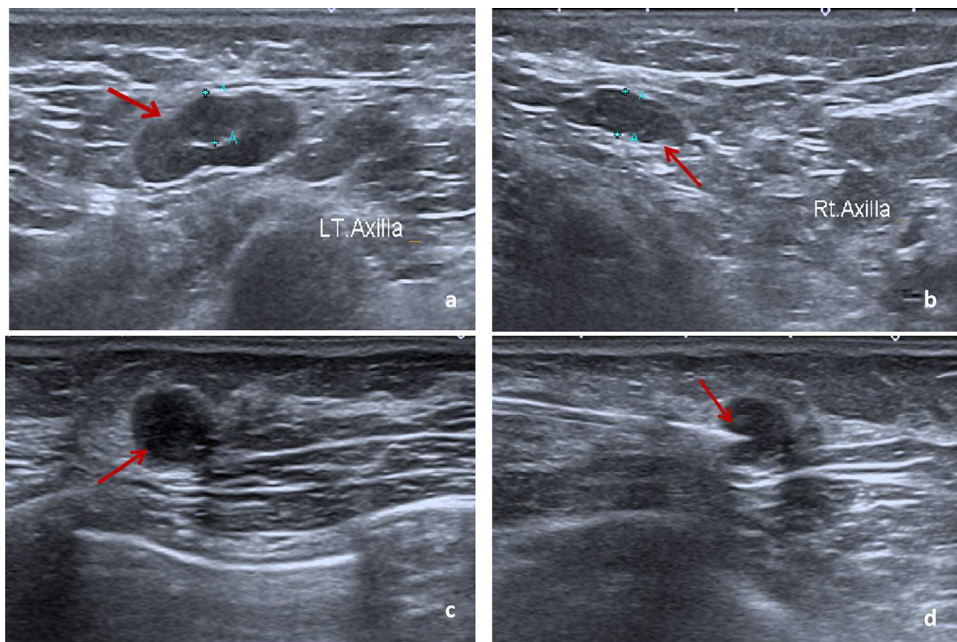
Ultrasound image showing enlarged axillary lymph nodes (arrow) with a nonuniformly thickened cortex involving the Lt axilla (A). Ultrasound image shows round lymph nodes (arrows) with a lost fatty hilum in the Rt axilla (B and C). Image shows ultrasound-guided biopsy of the round lymph node (arrow) in the Rt axilla (D). Lt, left; Rt, right.
